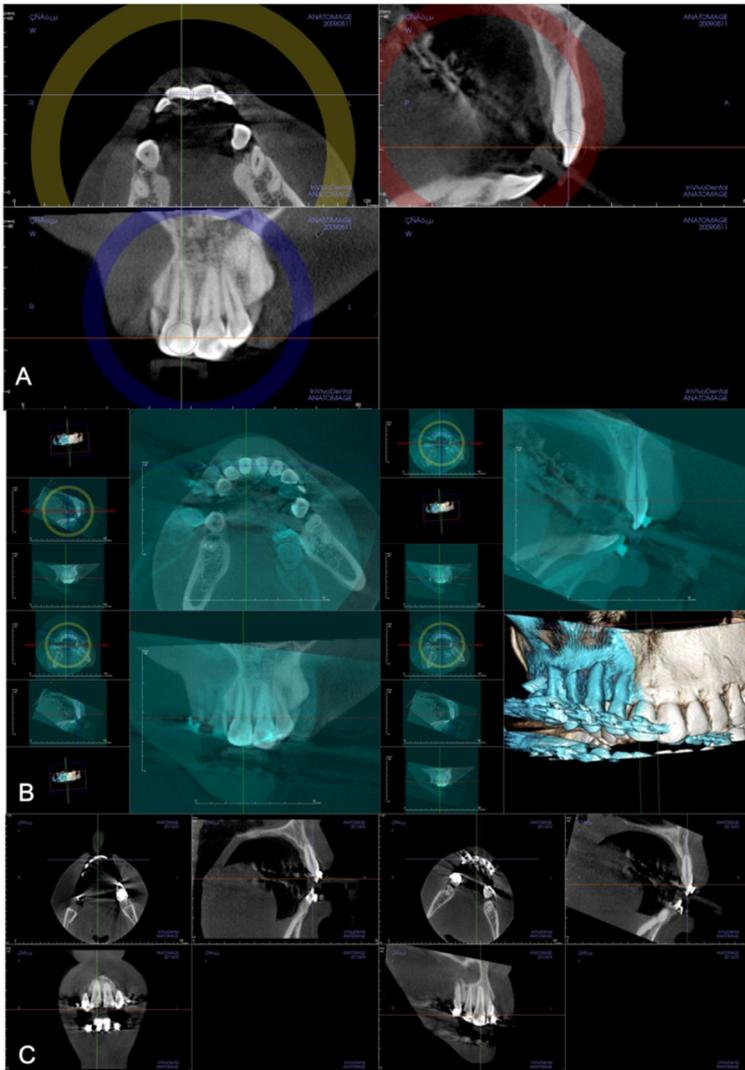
Three-dimensional (3D) superimposition of cone-beam computed tomography (CBCT) images of the right maxillary central incisor based on its long axis (LA) and clinical crown between the T1 and T2 stages. A. Setting of a LA of the maxillary central incisor on the sagittal image at the T1 stage. B. After 3D-superimposition by the best-fit method between the two sets of homologous landmarks in the T1 and T2 images, a manual refinement process is performed. C. Reorientation of the T2 image with the same LA of the T1 image through 3D-superimposition (left: raw image, right: reoriented image at the T2 stage)
